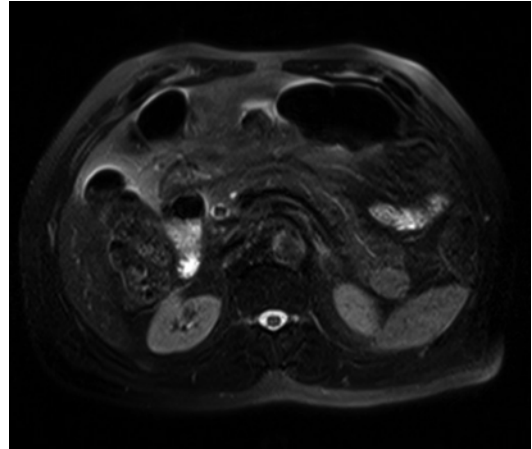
Magnetic resonance imaging (MRI) showed a solid, well-defined, hypervascular lesion in the tail of the pancreas. The lesion was located close to the spleen. It showed a similar enhancing pattern to the adjacent spleen. All these features are typical when diagnosing an intrapancreatic accessory spleen
